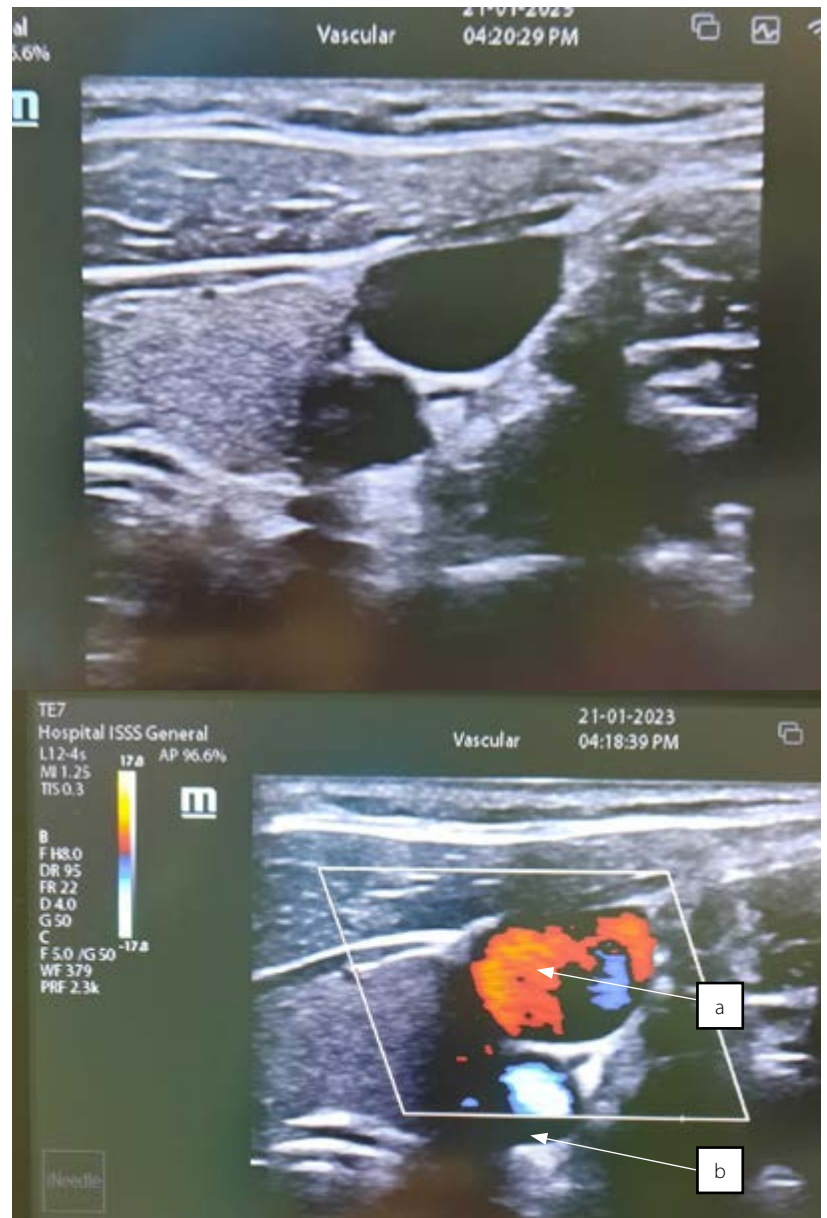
Ultrasound window showing the relation of the jugular vein and neighboring structures. a. Jugular vein. b. Carotid artery
